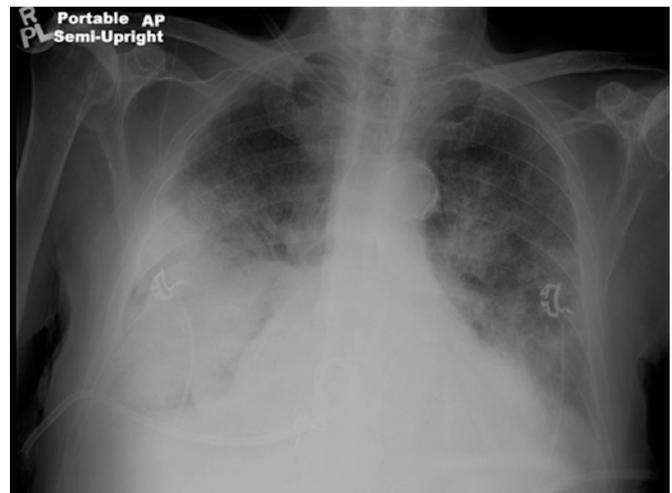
Post-thoracentesis x-ray taken during development of respiratory distress. This is notable for chest tube placement and significant rightsided pulmonary opacification.
